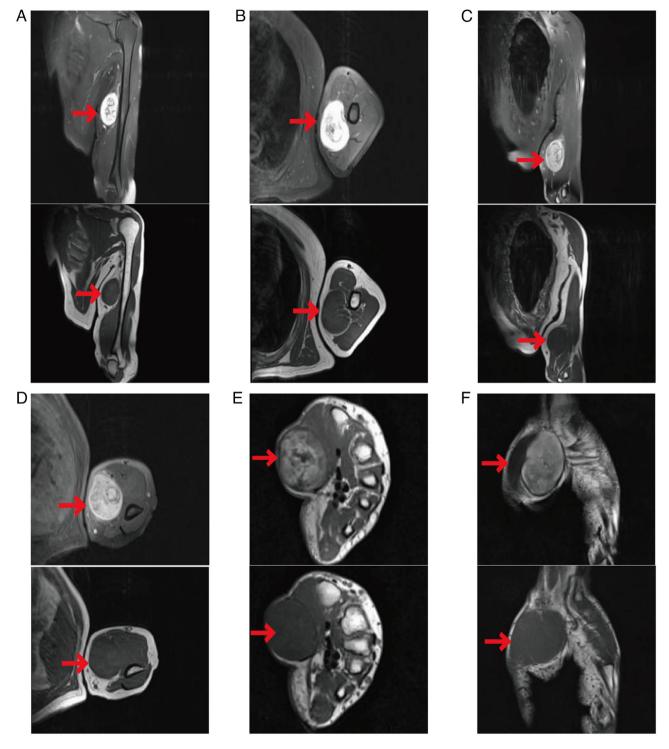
Magnetic resonance imaging analysis of the different planes of the tumor at admission shown as non-contrast and contrast-enhanced sequences. (A) Coronal plane scan of the mass in the proximal left upper arm. (B) Axial plane scan of the mass in the proximal left upper arm. (C) Coronal scan of the distal left upper arm mass. (D) Axial plane scan of the distal left upper arm mass. (E) T1-weighted and (F) T2-weighted images of the left-hand mass at the thenar muscles. The red arrow in each image indicates the tumor.
